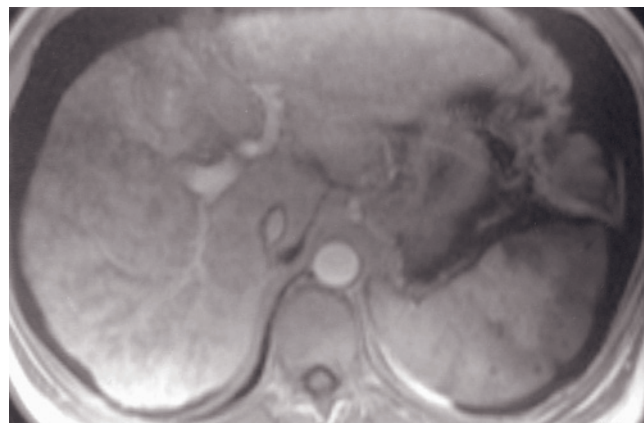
HCC with peritoneal spread. Fat-suppressed T2-weighted SS-ETSE (*a*), SGE (*b*), and immediate (*c*) and 90-s fat-suppressed postgadolinium SGE (*d*) images. The liver is small and irregular in contour, compatible with cirrhosis. There is a small exophytic HCC in the right hepatic lobe that demonstrates isointensity on T2 (*a*), slight hyperintensity on T1 (*b*), intense enhancement immediately after contrast administration (*c*), and washout with capsular enhancement on the late image (*d*), consistent with HCC. Note the peritoneum-based mass (arrow, *d*) in the left upper abdomen, near the spleen, consistent with a peritoneal metastasis from HCC.
